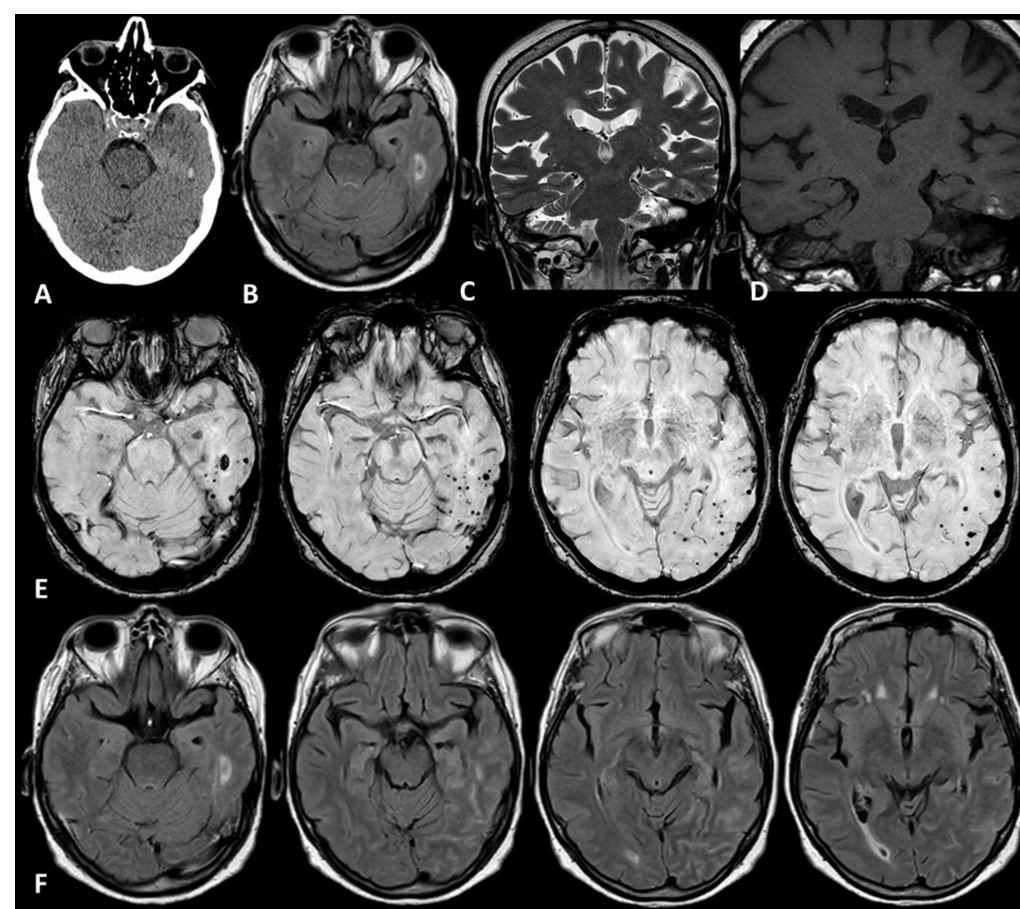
Neuroradiological investigations at the baseline, showing the small left temporal ICH on NCCT (A) and the MRI findings (B-F). B shows the axial FLAIR slice corresponding to CT on A; C and D show the coronal T1W and T2W slice, respectively, corresponding to the level of the left temporal ICH. E highlights the hemorrhagic burden in SWI. F shows the sequential slices of post-contrast FLAIR.
